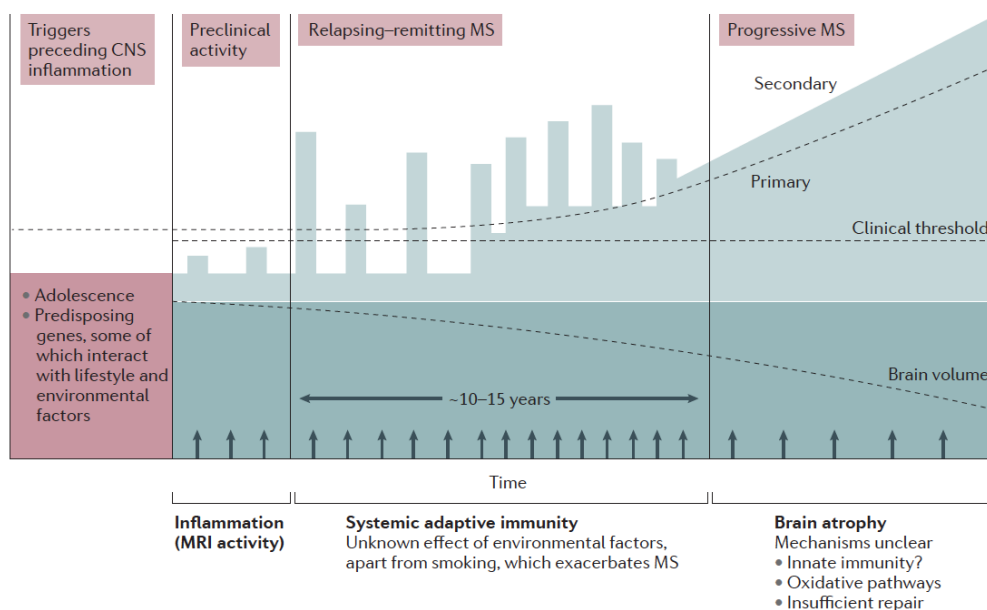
Progression of multiple sclerosis. Different risk factors play a role during subclinical phase of disease triggering CNS inflammation (*red area*). Progression of MS takes several years (*green area*). Bars denote inflammatory events that cause damage to CNS, although some of which do not achieve clinical thresholds. Arrows show episodes of new inflammation detected by MRI, that results more frequent than clinical relapses (Picture adapted from Olsson T et al., *Nat Rev Neurol*, 2016).
